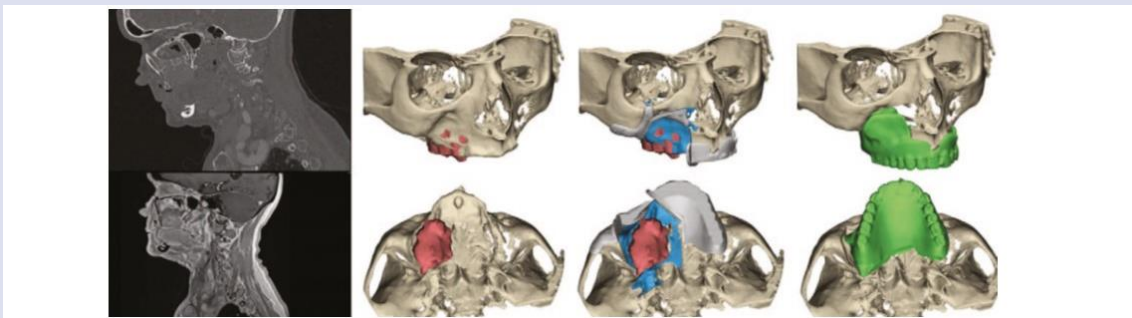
In a case of maxillary malignant lesion (red), CT and MRI data are used for preoperative 3D planning of bone resection (blue), guide design (gray) and obturator (green) (Glas 2020).
